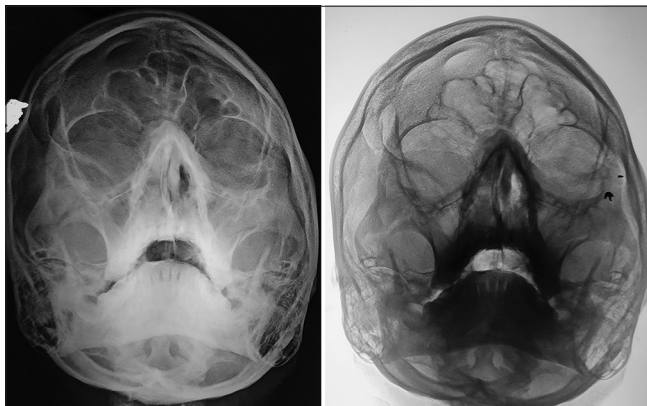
Conventional radiograph (paranasal sinus). Fracture line seen below frontonasal suture and infra orbital margin on right side
